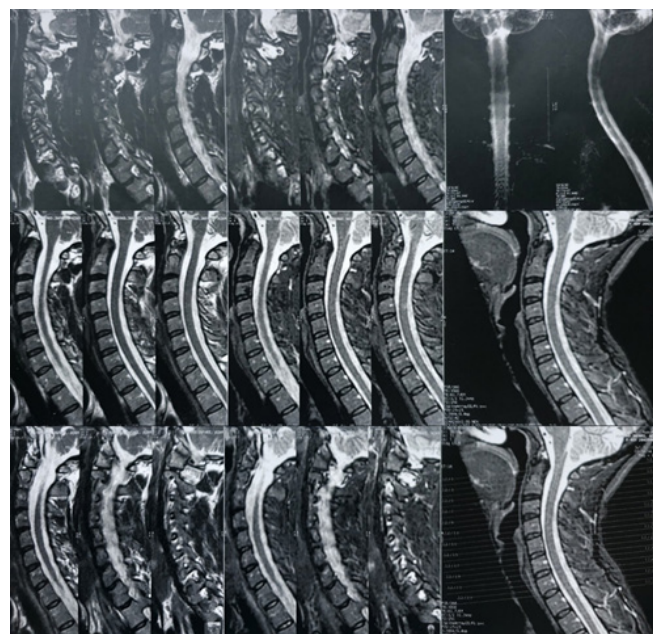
Before exosome; Cervical spine MRI with contrast by technique of Sagittal T1, T2 and selected T2W images was done. Findings as follows: Single Small T2/STIR high signal Lesion in cervical cord at C4 level in favor of MS. Plaque without enhancement.
